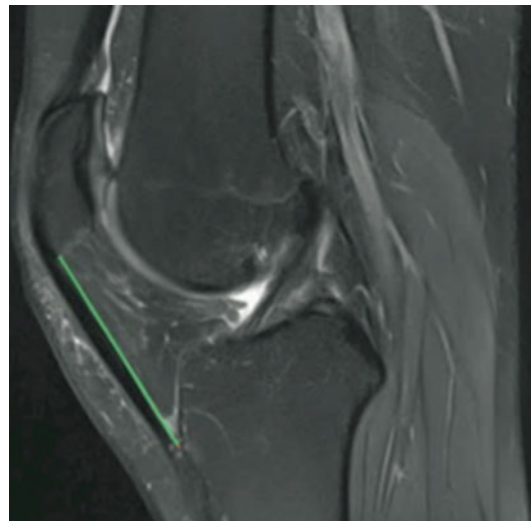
Patellar tendon length measured with MRI
